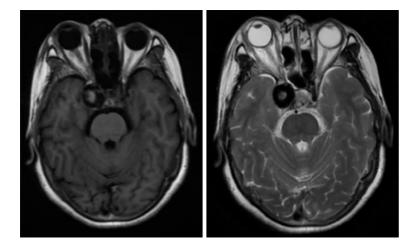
Brain magnetic resonance imaging revealed a right-sided aneurysm, with tortuous and increased vascular shadow in the posterior space of the right eye.
